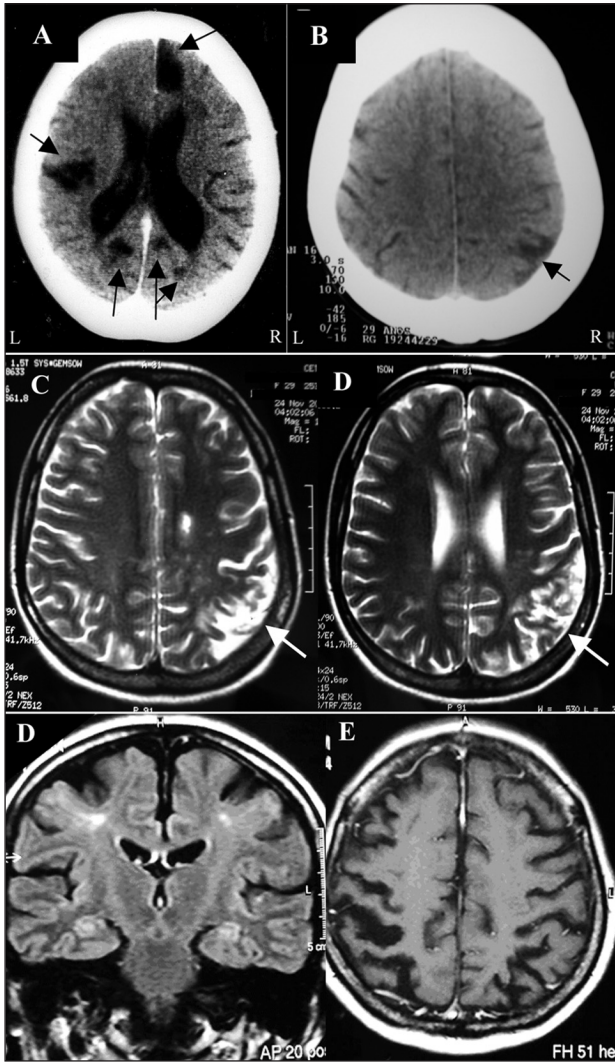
Cranial CT showing volumetric reduction of the cerebral hemisphere and hypodense areas in the right-temporal, left-frontal and bilateral occipital regions compatible with infarctions (arrows) in patient number one (A) and an area of cerebral infarction in the left parietal region (arrows) in patient number two (B). T2-weighted MRI showing area in keeping with cranial CT (arrows) in patient number two (C) and cerebral atrophy with anomalous signals in the subcortical white matter in patient number three in coronal (D) and axial sections (E).
